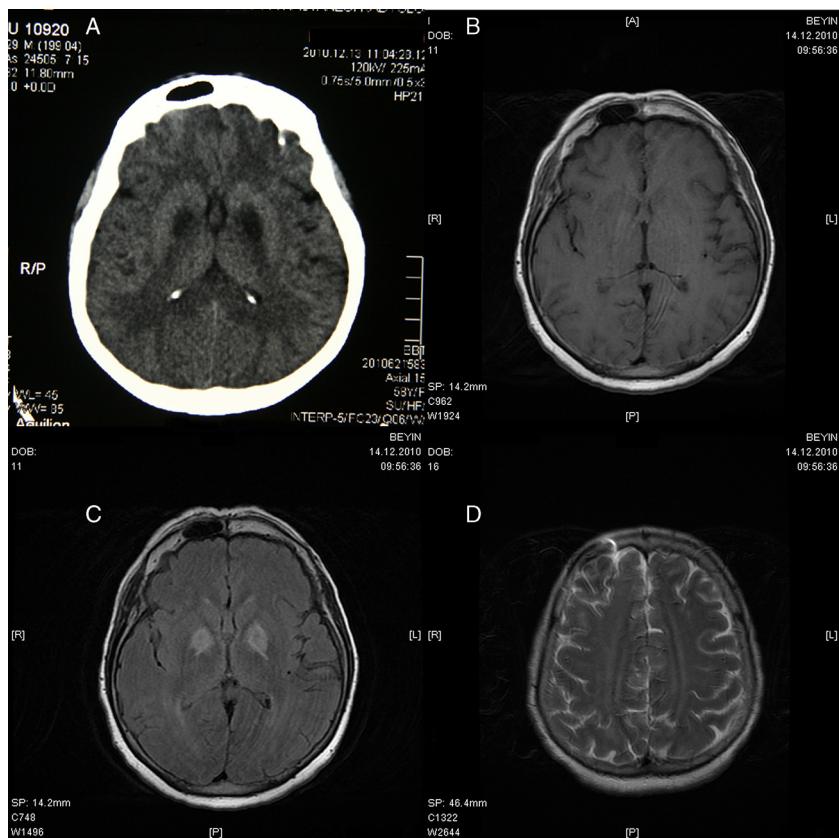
(A) Axial CT, (B) axial T1 MRI, (C) axial T2 MRI, and (D) axial T2 MRI (30th day) of Case 2.
